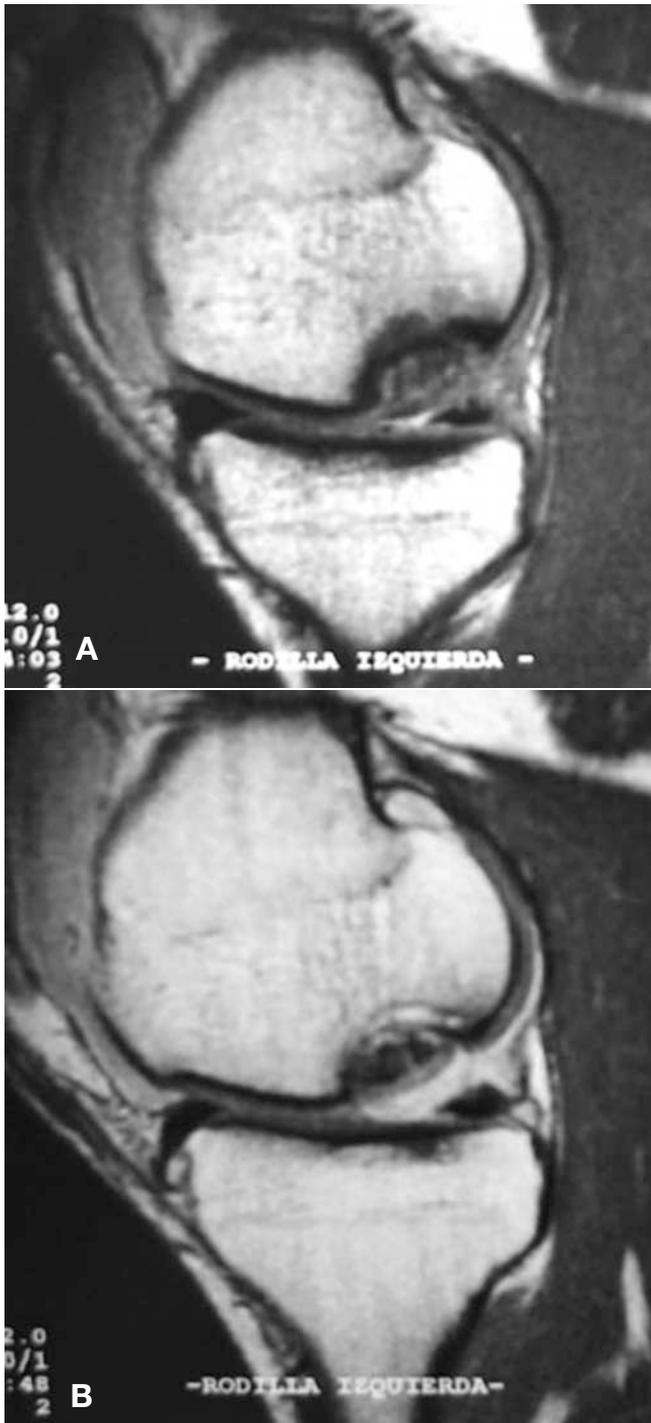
An MRI of the patient with an abnormal result in the International Knee Documentation Committee evaluation. A, sagittal image of the preoperative MRI; B, postoperative MRI showing disintegration of the osteochondral fragment.
